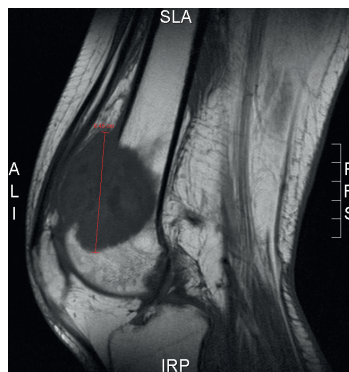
MRI scan of a patient with osteosarcoma in the distal femur region (dark area).
